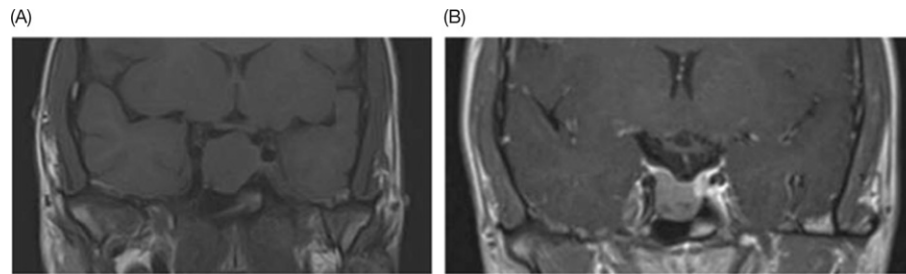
MRI pituitary showing a macroprolactinoma (A) at diagnosis and (B) following 3-months of cabergoline therapy.
